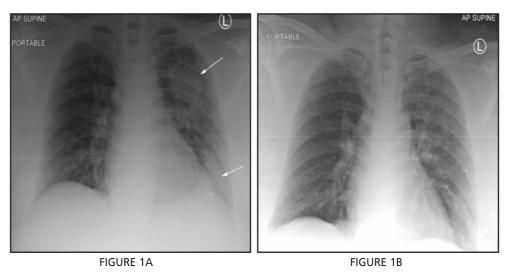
(A) Asymptomatic COVID-19 patient with consolidation at the left upper zone (arrow) and ground glass opacities at the left lower zone in the baseline radiograph. (B) Resolution of the lung abnormalities on day 5 of admission.
